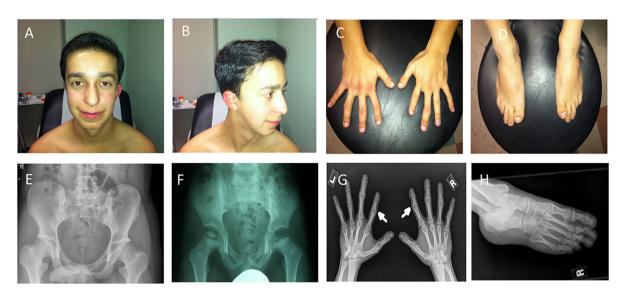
A: Case 1 reveals a prominent nose with a bulbous tip. B: Lateral view of the face revealing small, low-set ears. C: Dorsum of hands showing unusually angulated fingers with prominent joints D: Unusual feet with prominent 2nd and 3rd toes, and pes planus. E and F: X-rays of the hips showing progression of severe Legg-Perthes disease at ages 6 years and 20 years, respectively. G: X-rays of the hands showing cone shaped epiphysis of the phalanges at 20 years. H: X-rays of the feet showing prominent 2nd and 3rd toes, and cone shaped epiphyses at 20 years. [Color figure can be viewed at wileyonlinelibrary.com]
